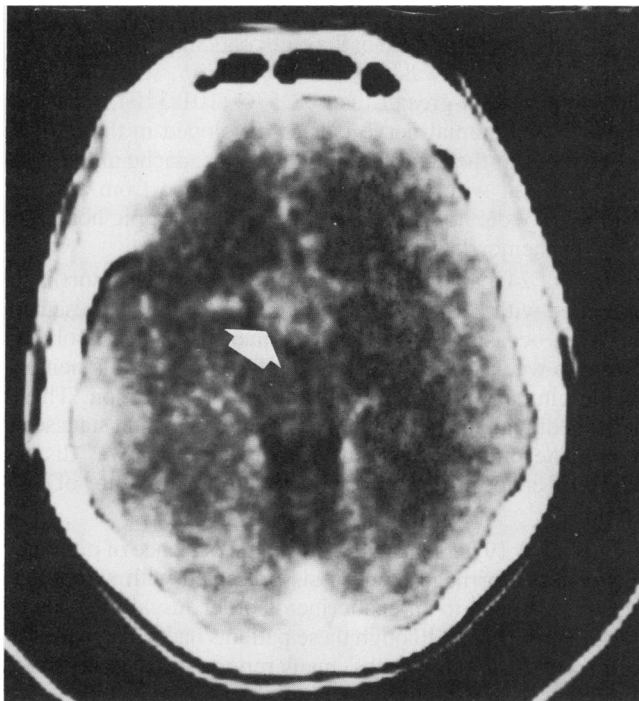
Computed tomographic scan of the head (without contrast) done within hours of the onset of symptoms in a patient with an acute presentation of pituitary adenoma hemorrhage. This scan shows a high-density mass in the suprasellar region from hemorrhage into the adenoma (arrow).
